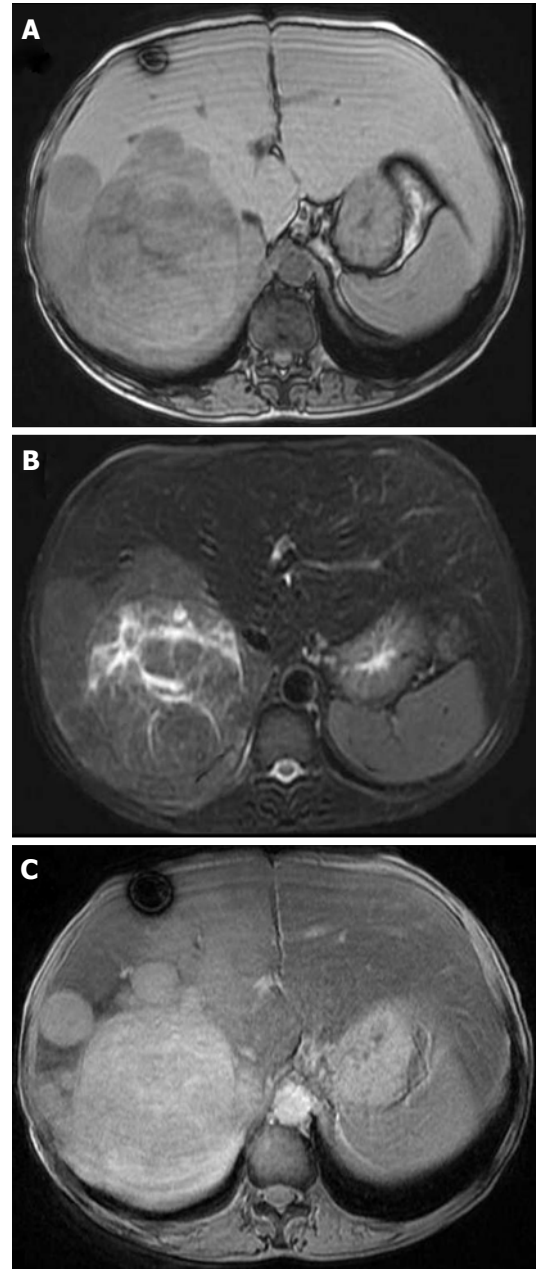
Magnetic resonance imaging. A: A low-intensity tumor in a T1WI; B: A high-intensity tumor in a T2WI; C: A tumor with low enhancement after resovist administration.
